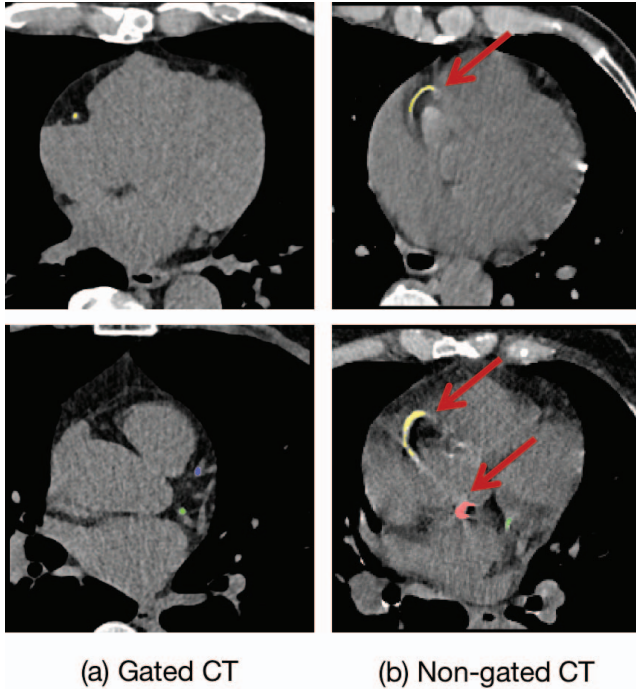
Examples of CAC on gated CT and non-gated CT images. Arrows indicate CAC with motion artifacts. Colors red, green, blue and yellow represent left main artery, left circumflex, left anterior descending and right coronary artery respectively.
